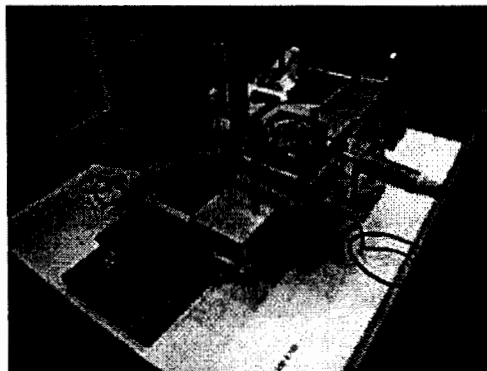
The prototype CT scanner [10]
